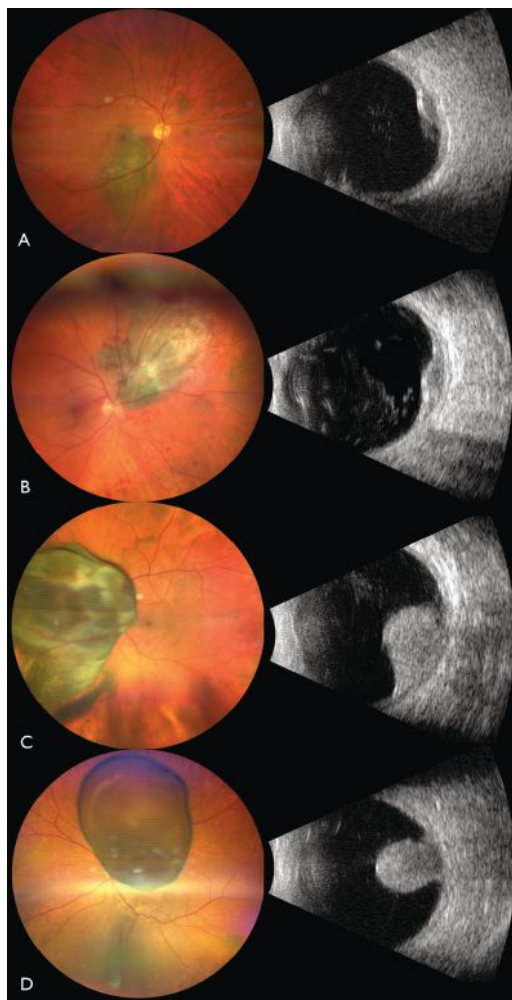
The Cancer Genome Atlas classification of uveal melanoma using fine needle aspiration biopsy. (A) TCGA Group A UM, measuring 11 mm x 7 mm in base with shallow subretinal fluid and orange pigment (left panel) and ultrasound showing an acoustically-hollow tumor with thickness of 3.1 mm (right panel). (B) TCGA Group B UM, measuring 12 mm x 11 mm in base with shallow subretinal fluid (left panel) and ultrasound showing an acoustically-hollow tumor with a thickness of 3.9 mm (right panel). (C) TCGA Group C UM overhanging the optic disc, measuring 18 mm x 17 mm in base with shallow subretinal fluid (left panel) and ultrasound showing a mushroom-shaped tumor with thickness of 10.7 mm (right panel). (D) TCGA Group D UM overhanging the optic disc, measuring 14 mm x 10 mm in base with shallow subretinal fluid and overlying retinal invasion (left panel) and ultrasound showing a mushroom-shaped tumor with thickness of 10.3 mm (right panel).
